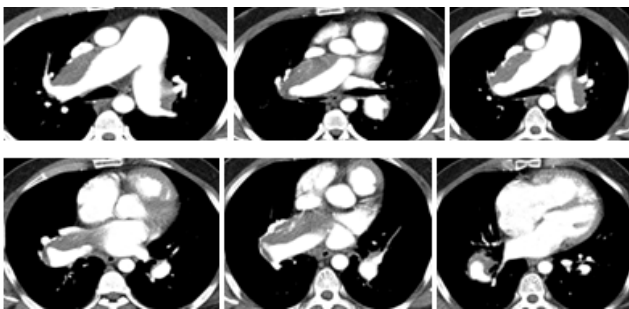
CT Chest with IV contrast Axial Images: Diffuse eccentric thickening of bilateral main pulmonary artery of the intimal surface, more on right side (post stenotic dilatation) which extends to major lower lobar (inferior) pulmonary arteries, more on right side with luminal narrowing of right main pulmonary artery with patent lumen on both sides. No acute thrombosis. Decreased diameter of distal segmental pulmonary arteries.
